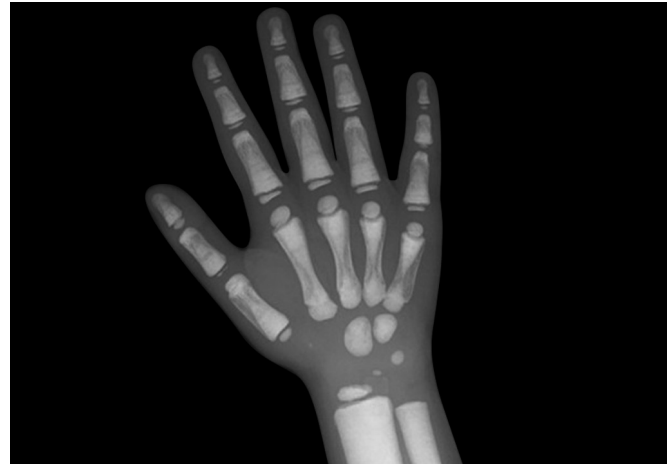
X-ray of hand AP view showing bone within bone appearance in a patient of osteopetrosis.
